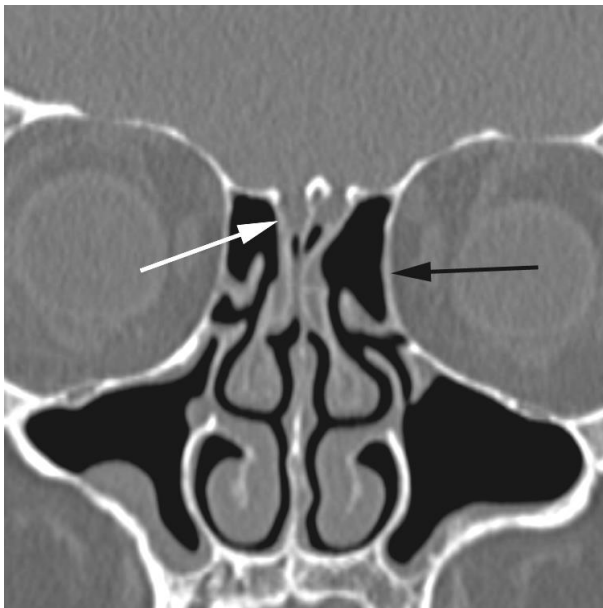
Possible hazards to functional endoscopic sinus surgery in a 64 year old woman with recurrent sinusitis symptoms. Coronal CT study (bone windows) shows a low-lying cribriform plate with a thin bony covering (white arrow) as well as a thin bony lamina papricea (black arrow).
